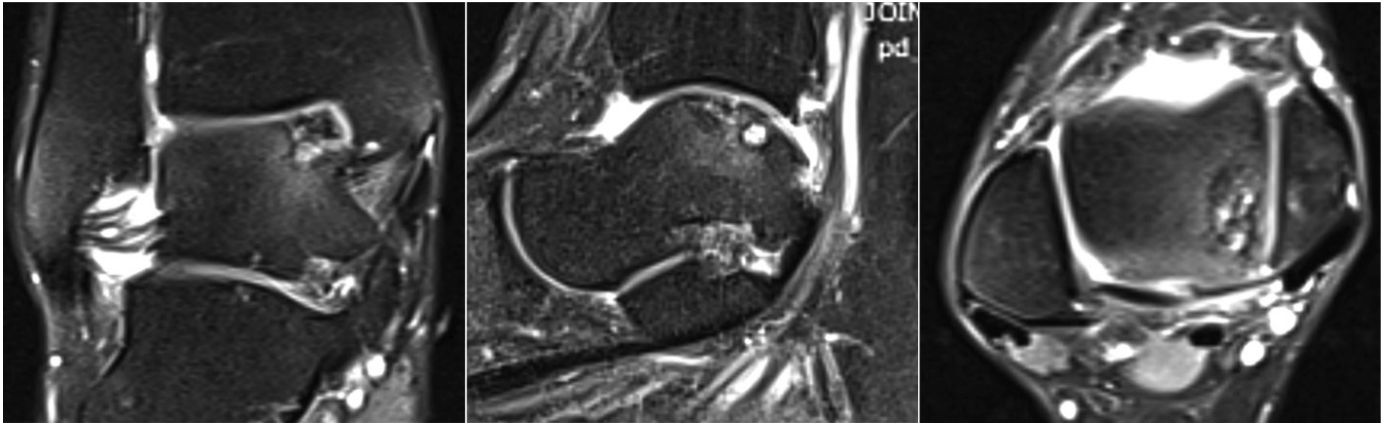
MRI scans of the right ankle joint. Appearance and localization of the osteochondral defect of the talus.
